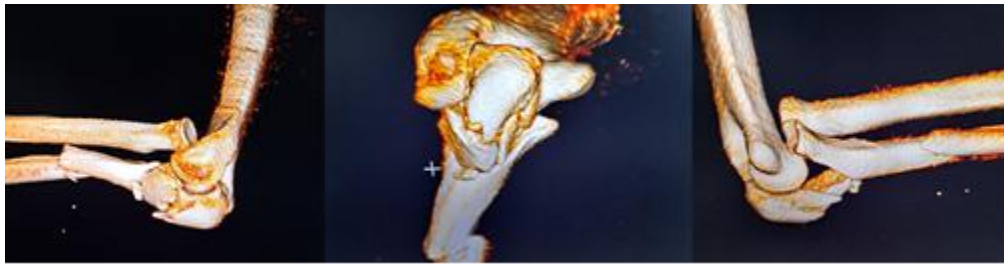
Preoperative computed tomography imaging revealed a Monteggia fracture associated with a comminuted fracture-dislocation of the olecranon
